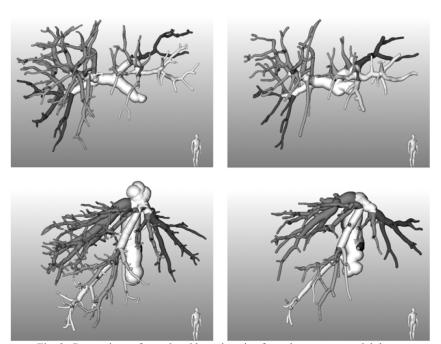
Comparison of portal and hepatic veins from the same potential donor segmented in CT (left) and MRI (right) data.
